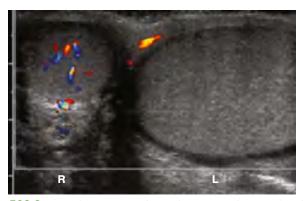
Testicular torsion and axis change. A color Doppler ultrasound in the transverse plane shows color flow in the right testicle. The right testicle is oval to circular because it has been evaluated in the transverse plane. The left testicle is elongated as if it is in the longitudinal plane, indicating an abnormal lie within the scrotum worrisome for torsion. Lack of color Doppler flow in the left testicle confirms left testicular torsion. (From Coley BD, ed. Caffey's Pediatric Diagnostic Imaging, 13th ed. Philadelphia: Elsevier; 2019: Fig. 125-13, p. 1195.)
